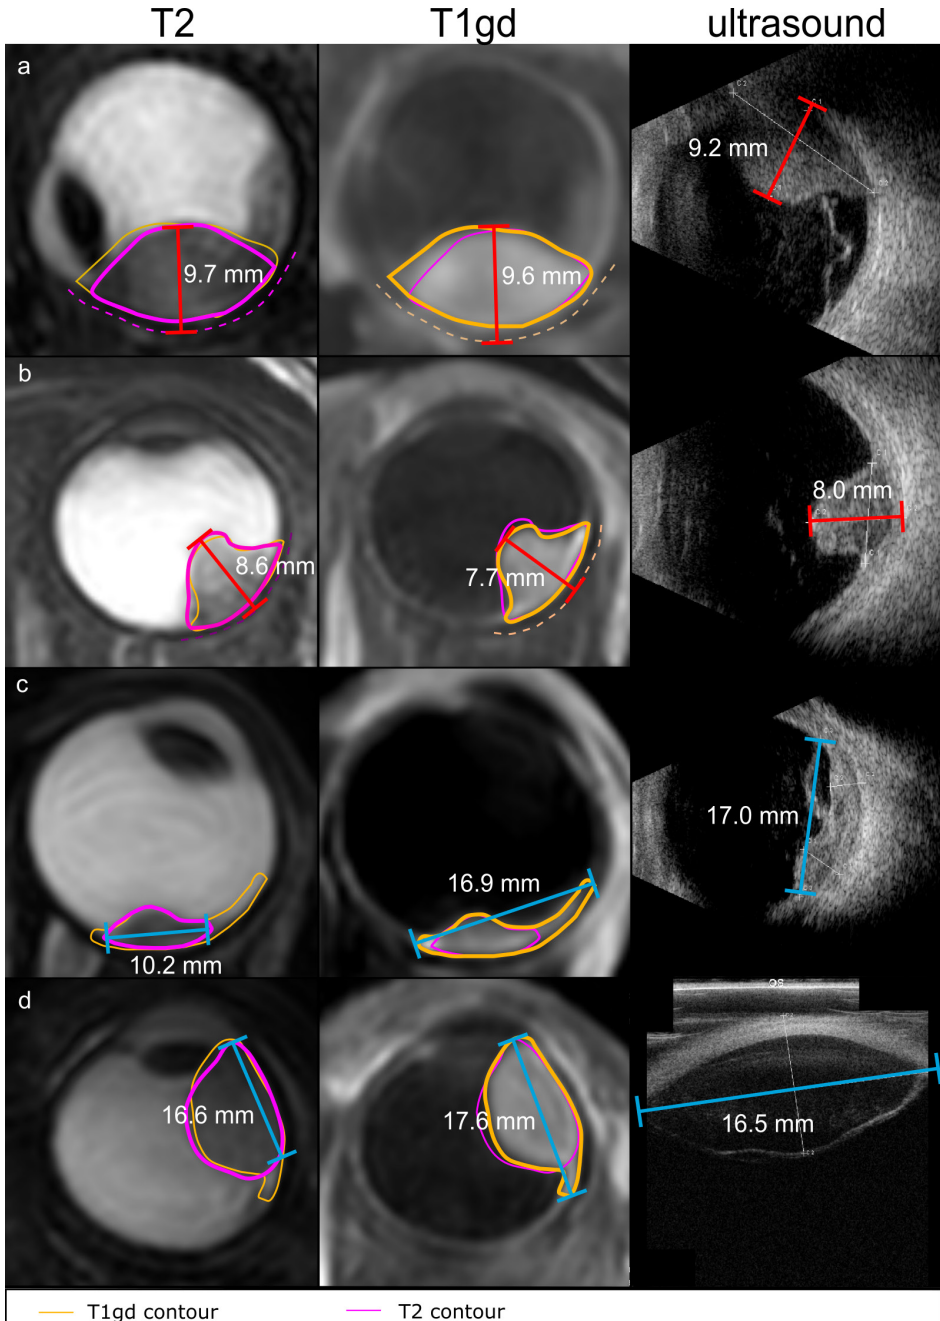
Prominence and LBD measurement on T2-weighted MRI (left column), T1gd-weighted MRI (middle column) and US (right column). (a) Prominence was generally similar on T1gd and T2. (b) The largest difference between T2 and T1gd prominence was 0.9 mm. (c,d) LBD was generally larger on T1gd.
